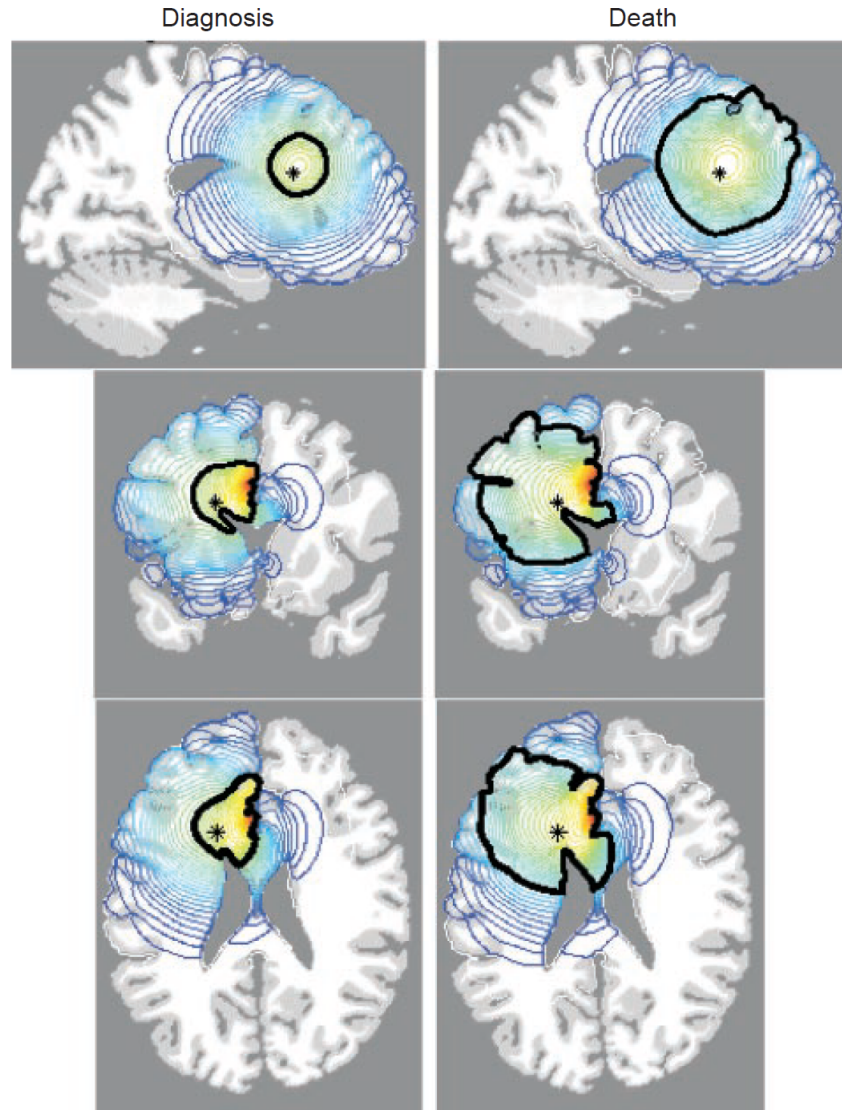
Sections of the virtual human brain intersecting the site of the glioma originating in the superior frontal region denoted by an asterisk (\*). The left column of brain sections corresponds to the tumor at diagnosis whereas the right column represents the same tumor at death. Red denotes a high density of tumor cells while blue denotes a low density. A thick black contour defines the edge of the tumor detectable by enhanced CT. Cell migration was performed in a truly three-dimensional solid representation of the brain. The elapsed time between diagnosis and death for this virtual glioma is approximately 158 days. (image taken from [130]).
